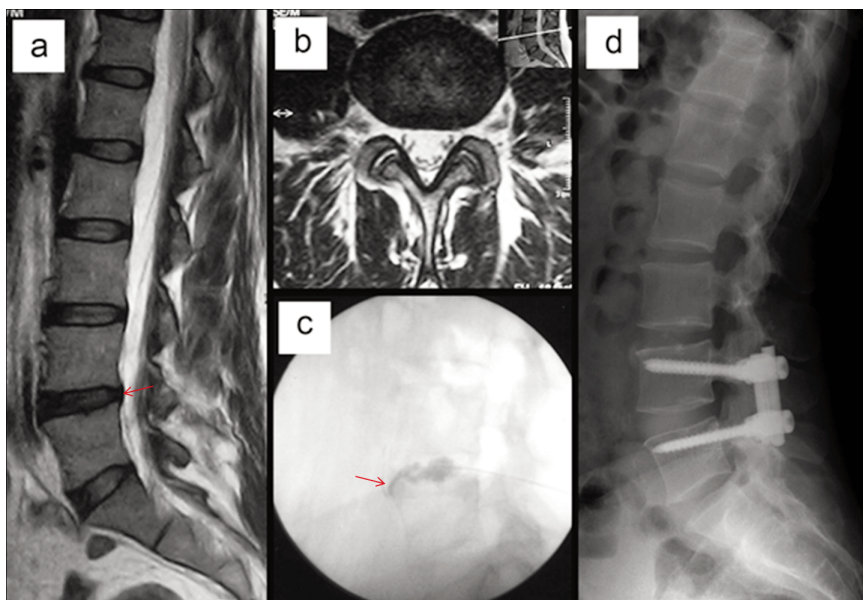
A) Mild degeneration findings of L4-5 disc with sagittal T2 weighted magnetic resonance imaging view; B) axial view; C) leakage of contrast medium through anterior annulus defect; d)postoperative stabilization of the patient's with dynamic screws (Cosmic-Ulrich company).
